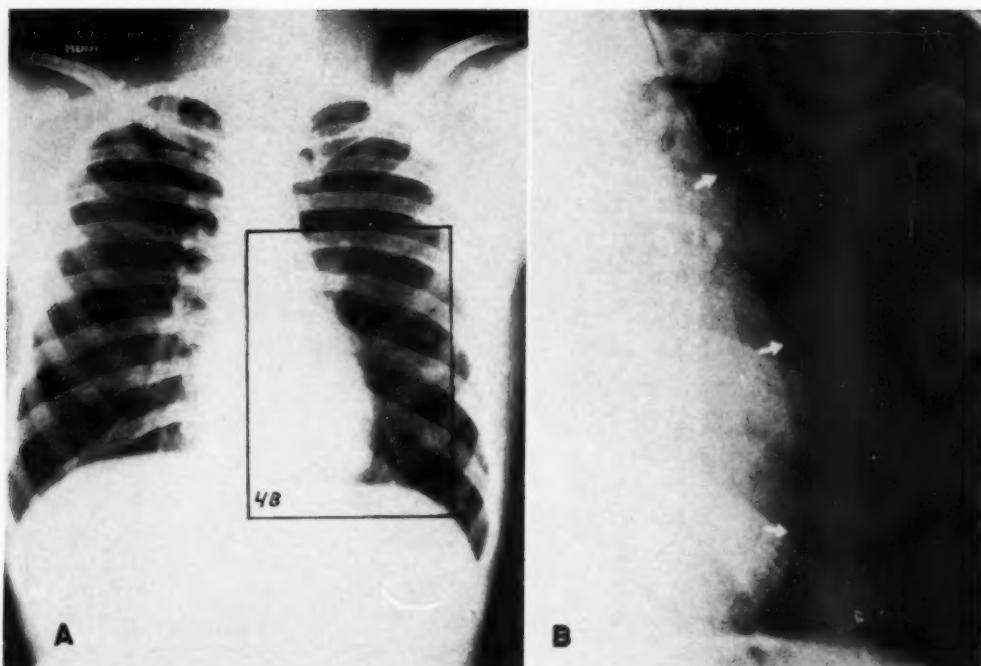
A. Roentgenogram of chest of a 17-year-old male, demonstrating the normal subepicardial-pericardial shadow pattern. B. Enlarged reproduction of indicated segment in 4A.
